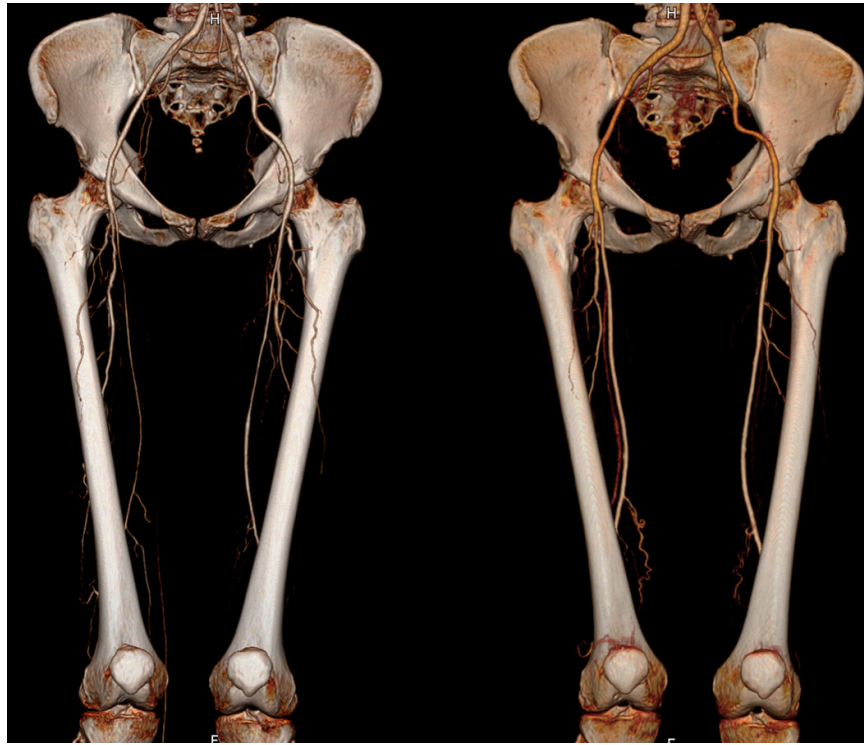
Three dimensional CT-angiogram reconstruction images in a GCA patient with LE vasculitis shows smooth narrowed tapering of both superficial femoral arteries (A). After corticosteroid treatment there was marked improvement with minimal residual stenosis (B).
